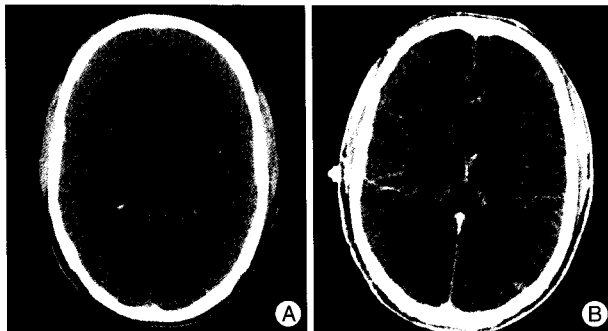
Brain CT scan at admission. A : Non-contrast of axial CT scan reveals innumerable cysts with hyperdense "dot" in the brain parenchyma. B : Contrast of axial CT scan demonstrates numerous cysticerci with vesicular stage.
